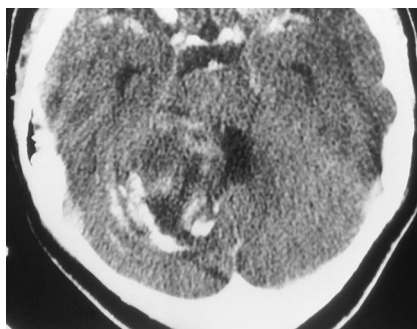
Post contrast axial CT shows a ganglioglioma in the right cerebellum. The tumor has mass effect on the fourth ventricle and is inhomogenous in density. The calcifications have a bizarre pattern and follow the folia. In this case, ganglioglioma was considered the main differential diagnosis.
